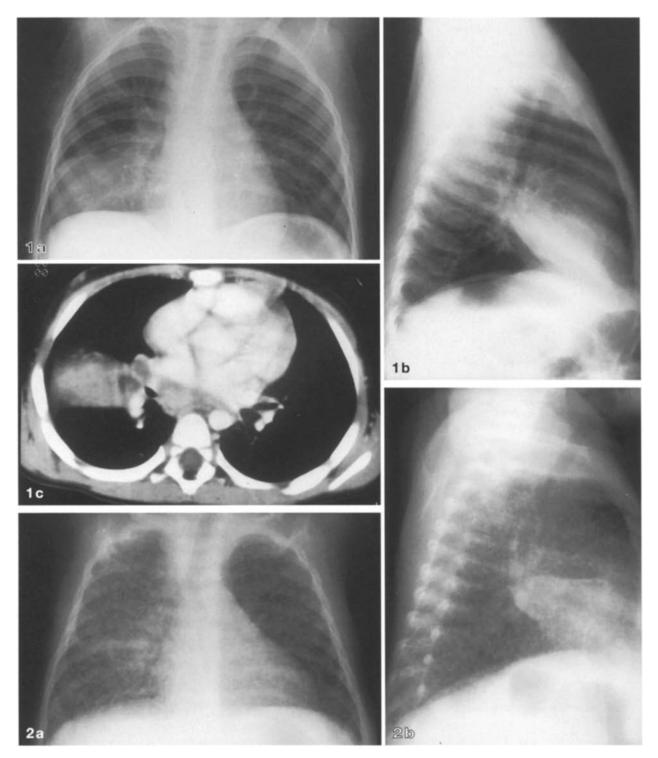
Primary pulmonary tuberculosis in a 2-year-old boy. a Anteroposterior chest radiograph shows right paratracheal lymph node enlargement and right middle lobe opacity. b Lateral chest radiograph confirms right middle lobe opacity with some volume loss. c CT scan demonstrates low-attenuation, enlarged right hilar lymph nodes and opacity in lateral segment of right middle lobe. Peripheral nodal enhancement is seen
